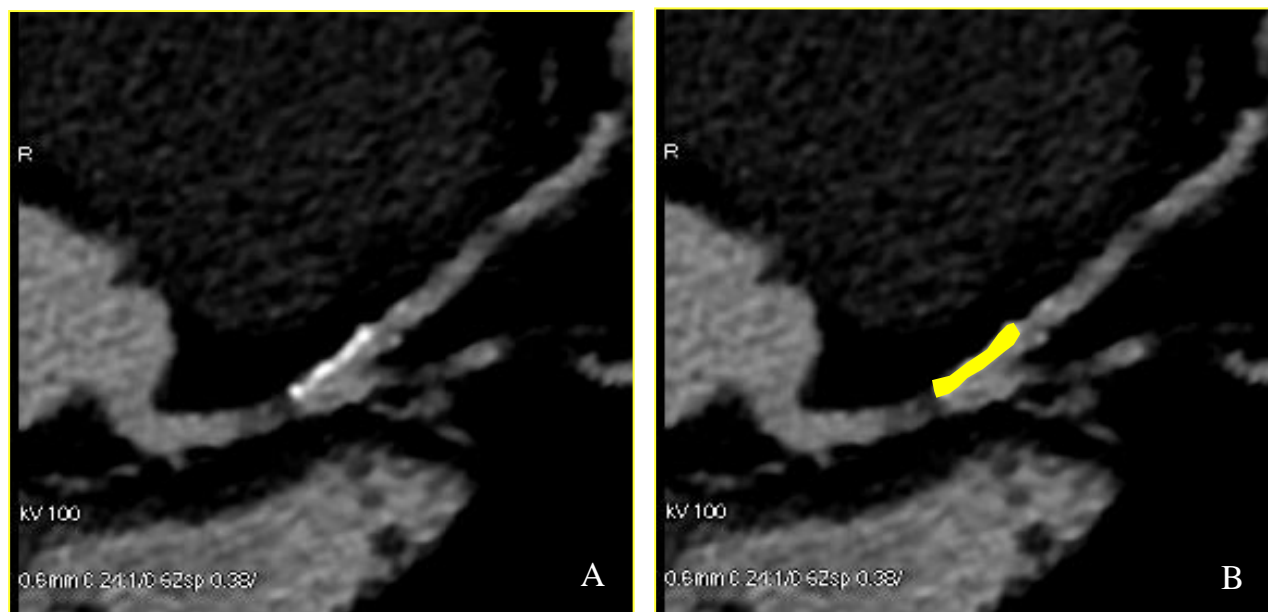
(A, B): Segmentation of calcium on non-contrast CT by identification of any structure with densities of 130 Hounsfield units (HU) or more and of an area of 1mm^2
